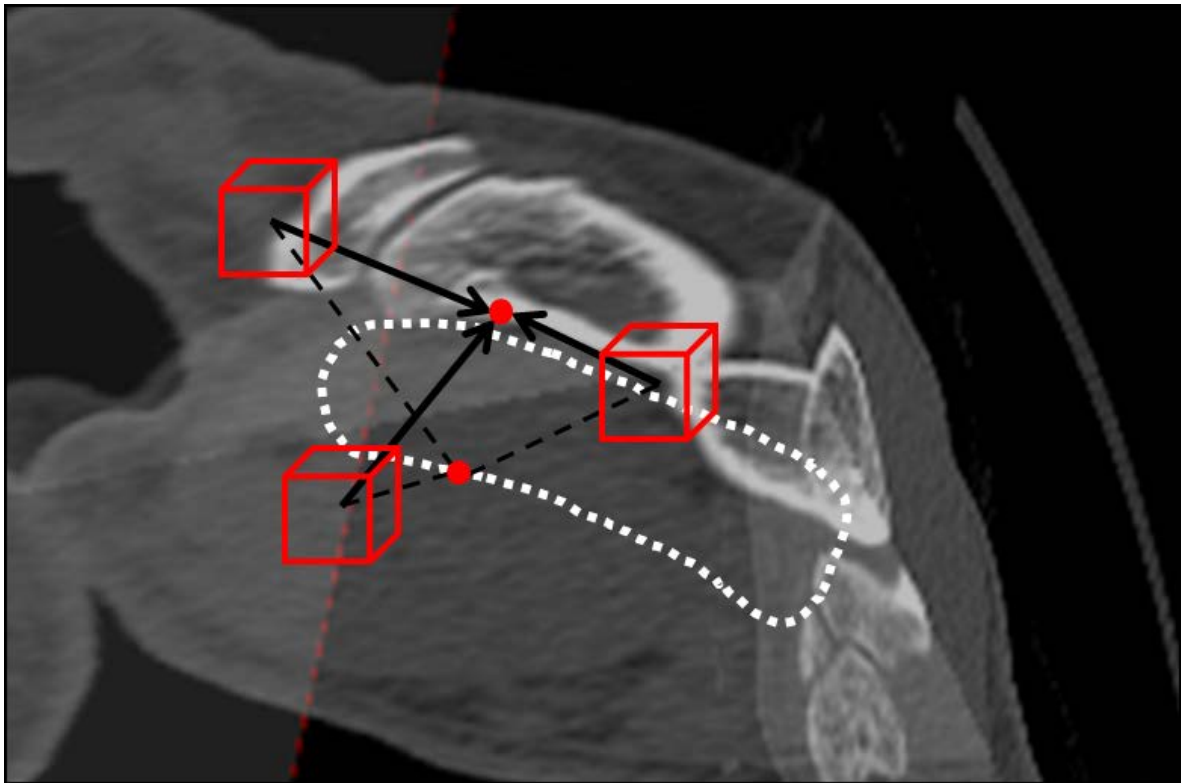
3D Haar-like features (red boxes) and corresponding displacements (arrows) are used to train a RF regressor on the spatial distribution of features around each node of the shape model mesh. During segmentation, the shape model mesh (white dotted line) is initialised and 3D Haar-like features (red boxes) are sampled (dashed lines) from the mesh node (red point on white dotted line). The regressor for each node uses the features to predict the correct location (arrow) of the node (red point) in the CT image.
